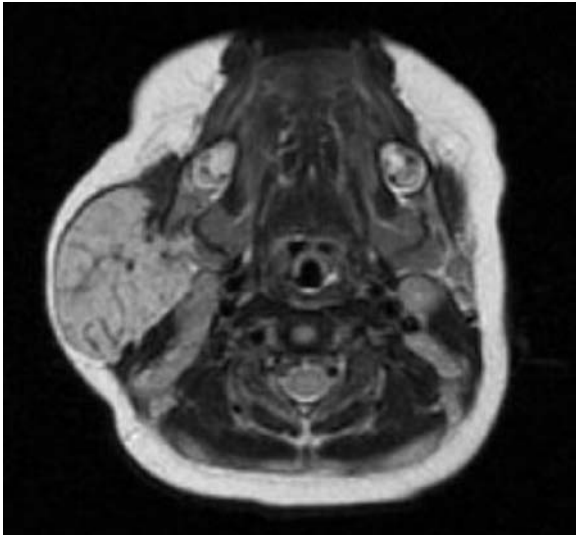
MRI demonstrating a hemangioma of the right parotid gland in a 6-month-old infant diagnosed radiographically and managed successfully with observation
